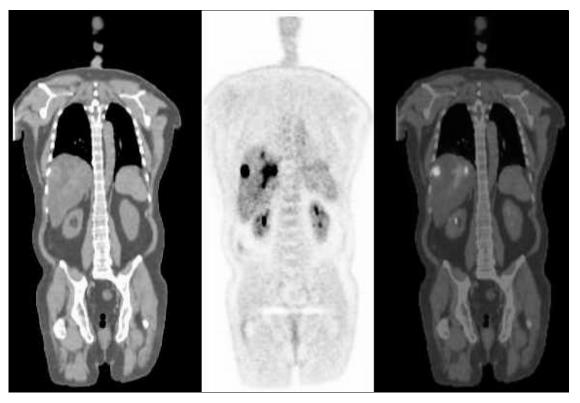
Coronal reformatted CT (left), PET (center) and fusion hybrid images (right) of multiple colorectal liver metastases. The metastases appear slightly hyperdens in a steatotic liver at the non-enhanced CT image, dark at the PET image and bright at the fused image.
